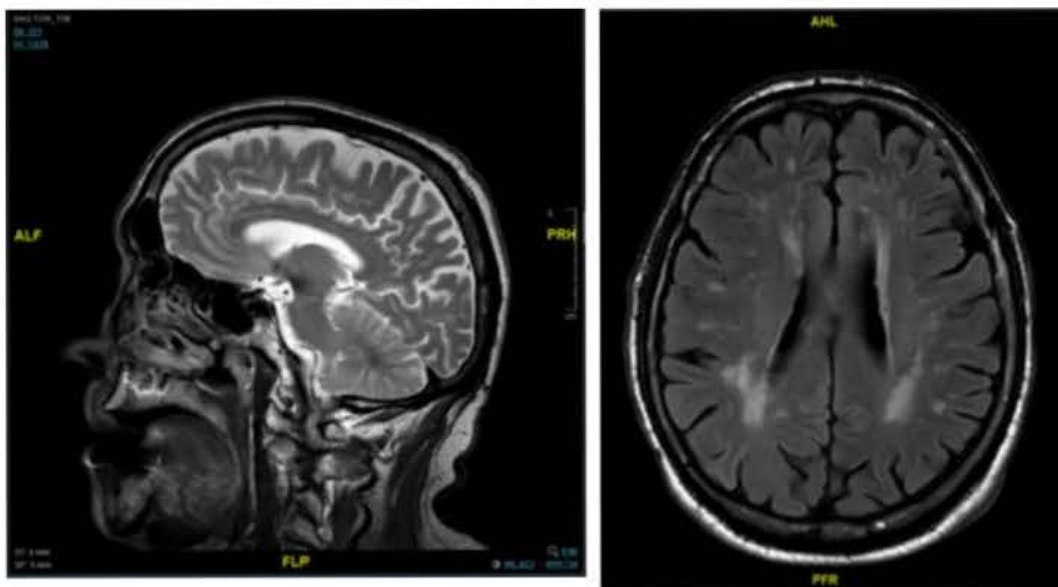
MRI: the axial view shows hyperintense periventricular foci. The sagittal view shows how the FTD pathological process mainly affects the frontotemporal regions.
